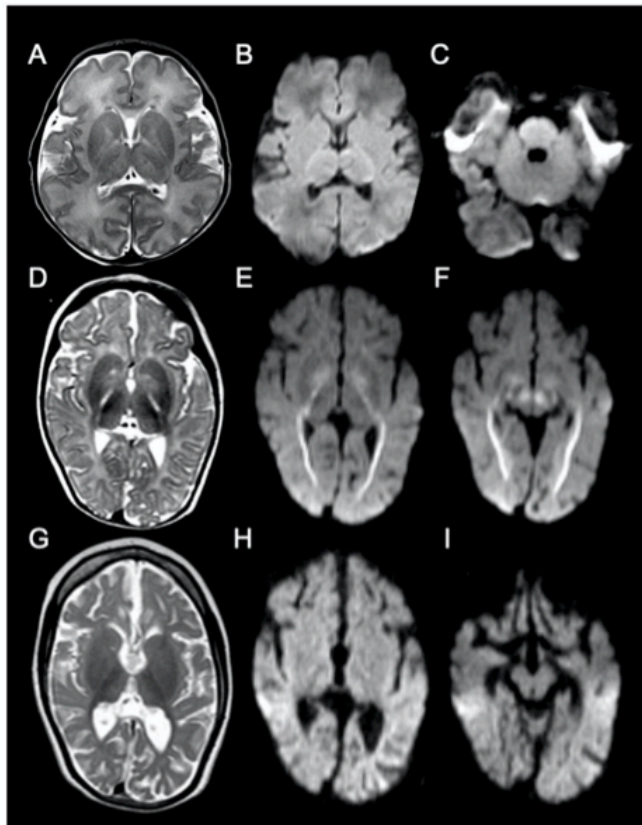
Neuroimaging. (d) MRI findings. MRI of P3 at age 6 days (A, B, C). T2-weighted image (A) shows no atrophy and no signal abnormalities. There is no restricted diffusion (B,C) on diffusion-weighted imaging (DWI, apparent-diffusion coefficient maps not shown). MRI of P1 at age 6 months (D, E, F) shows no atrophy, but moderately delayed myelination and T2-hyperintensity of the posterior limb of the internal capsule (PLIC; D). Restricted diffusion is seen in the optic radiation, PLIC (E), and decussation of the superior cerebellar peduncles (F). Mild diffusion restriction is seen in the globus pallidus (E). MRI of P1 at age 2 years and 8 months (G, H, I) shows seriously deficient myelination and severe cerebral atrophy (G). Restricted diffusion is no longer present (H, I). DEE 35, developmental and epileptic
